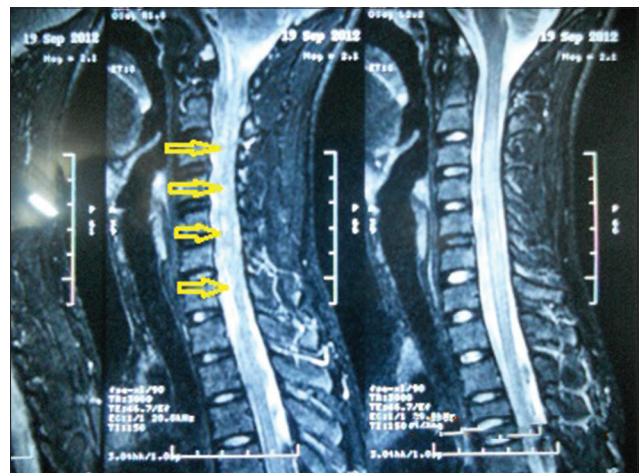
Cervico-thoracic spinal cord magnetic resonance imaging in the sagittal plane T2-weighted image showing increased signal intensity extending from cervicomedullary junction up to the level of T4 vertebra with mild expansion of the cord, involving central gray matter, and enhancing in T1 contrast images suggestive of myelitis
